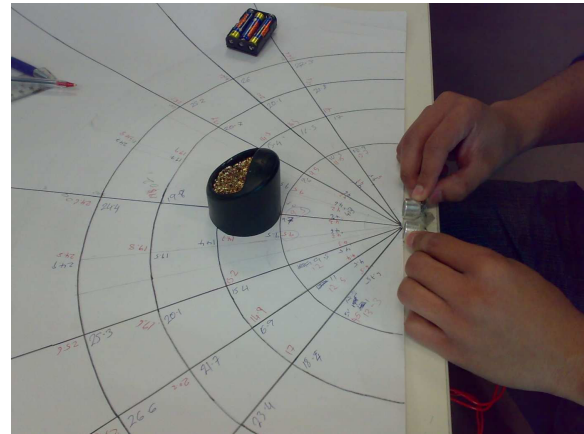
Beam angle chart for testing the ultrasound capabilities
